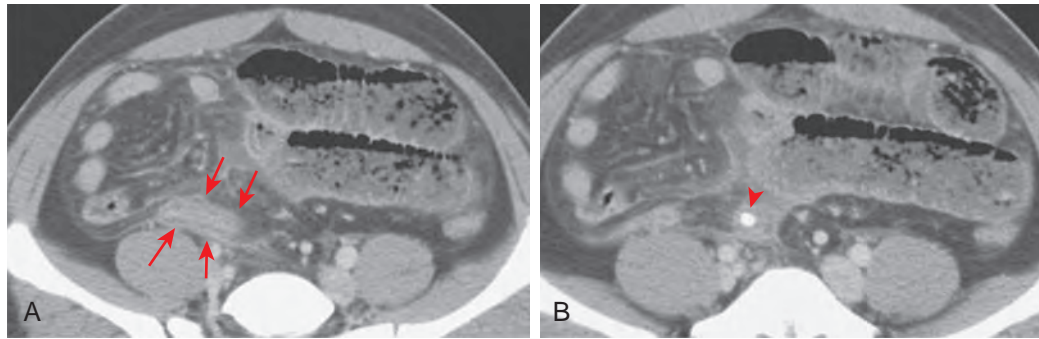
Small bowel obstruction from acute appendicitis. A. There are multiple dilated small bowel loops in the pelvis to the level of the abnormally distended, thick-walled, and enhancing appendix (arrows). B. A more superior CT scan shows a calcified appendicolith (arrowhead) near the appendiceal orifice.
